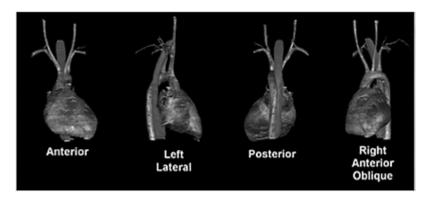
Anatomical relationship of the esophagus (pink) with the heart and aorta. The distal ascending aorta is clearly in the far field from the transesophageal probe, whereas the distal arch is a very near-field structure. (Images created with the Visible Human Dissector, Touch of Life Technologies, Colorado, USA.)
